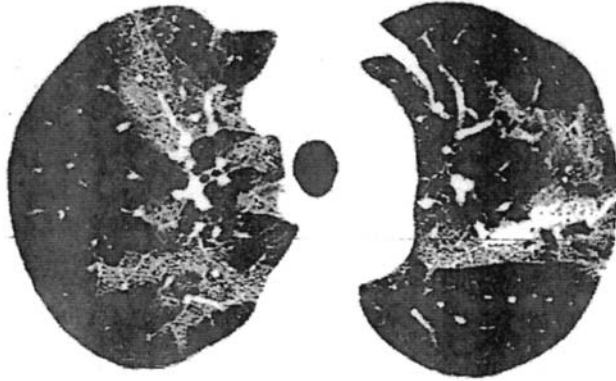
Acute hypersensitivity pneumonia (HP). HRCT scan from a 59 year-old woman with fever, cough, and dyspnea demonstrating dense focal alveolar (ground glass) opacities in a peribronchiolar distribution. Transbronchial lung biopsies demonstrated lymphocytic infiltrates, foamy macrophages, and non-caseating granulomas, consistent with HP. The disease cleared completely following institution of corticosteroids and avoidance of further exposure to molds. (Reproduced with permission. From Ref. 84.)
